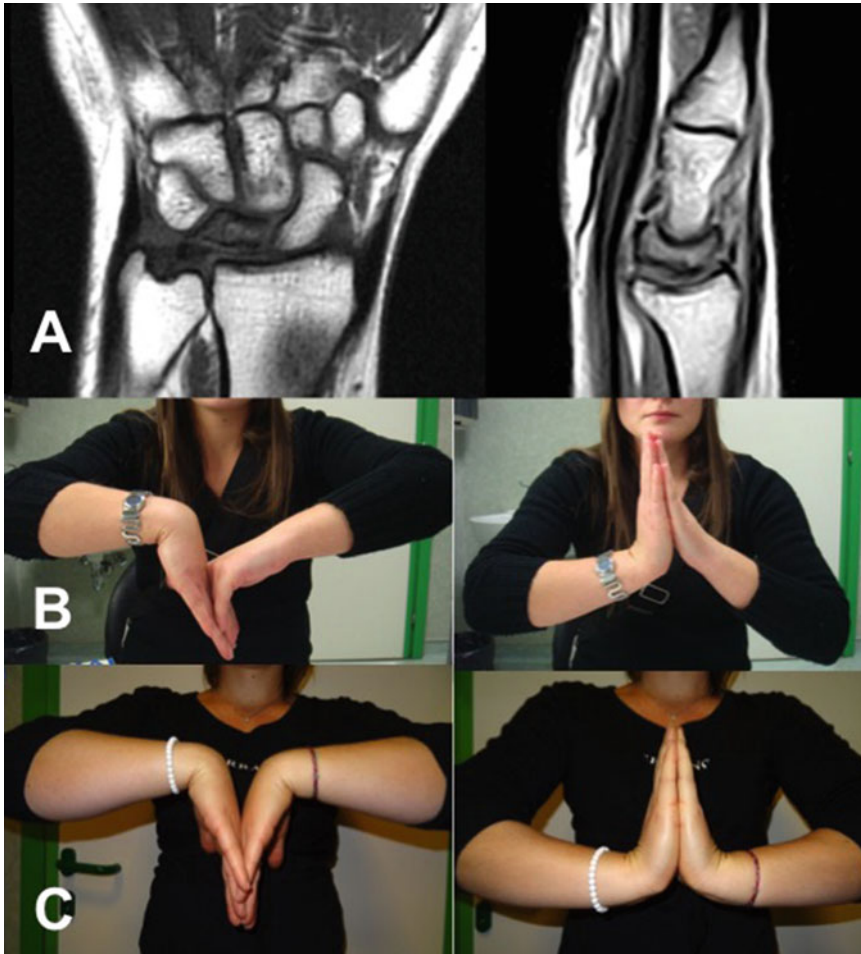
Clinical case: (a) Preoperative MRI imaging of a 24-year-old female diagnosed as Lichtman's stage 1. (b) Restricted preoperative flexion–extension range of motion. (c) Range of motion 3 years following surgery
